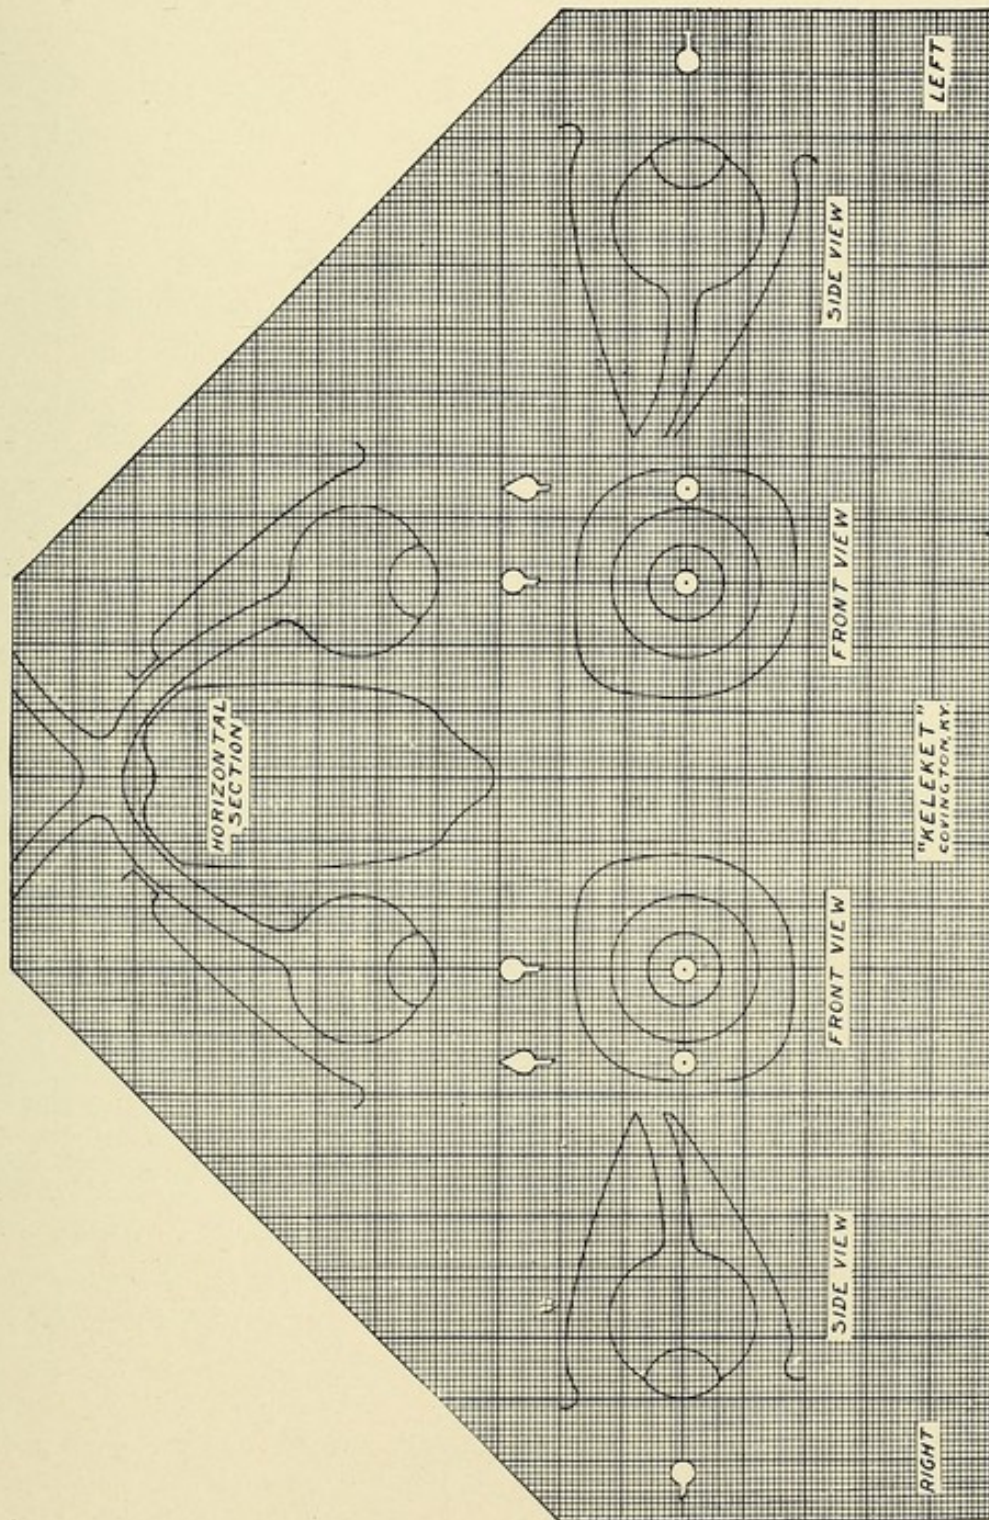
X-ray in eye surgery. Chart for locating foreign body in the eye. Reduced.
